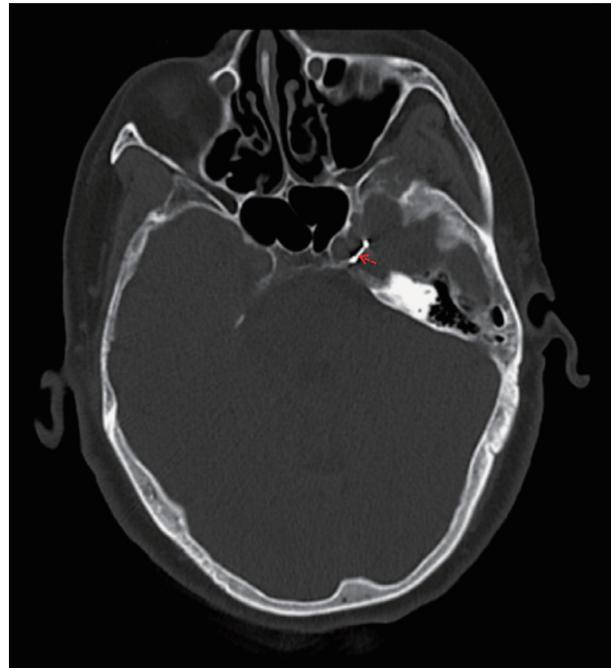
CT scan confirming the placement of the stimulation lead at the Gasserian ganglion. The dumbbell-shaped highlighter in the intracranial region is the SCS-implanted electrode. The red arrow points to the stimulation electrode. CT, computed tomography; SCS, spinal cord stimulator.
